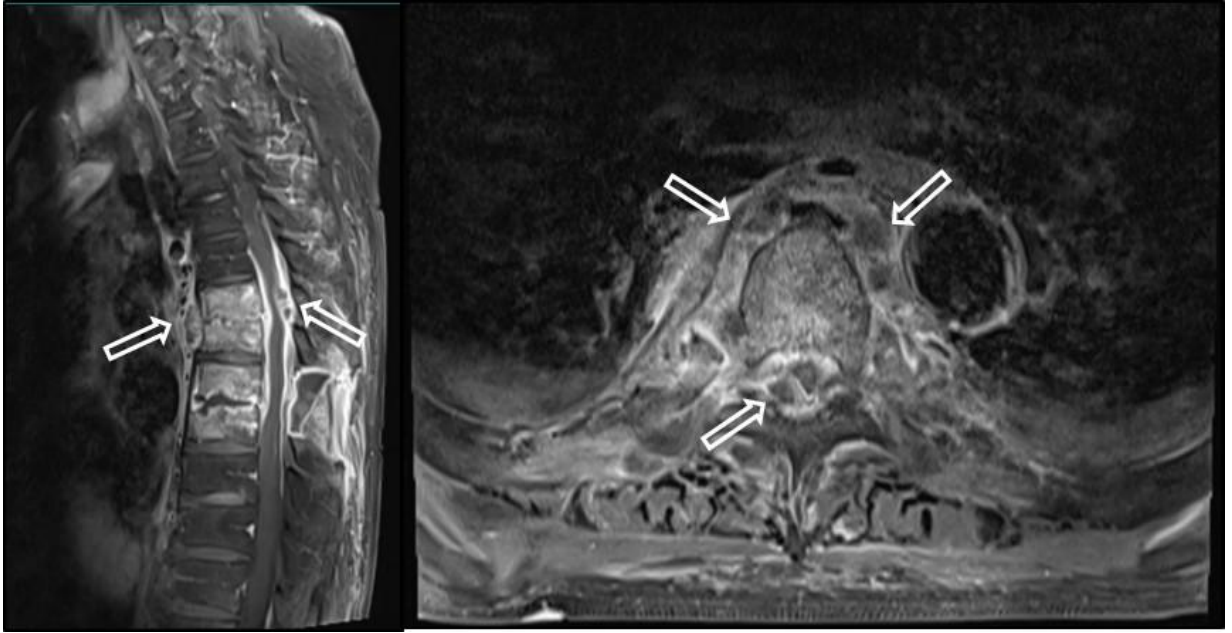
Thoracic spine T1-weighted magnetic resonance imaging with enhancement showed recurrent aggravated spondylitis with epidural abscess (white arrow) on the T6/7 and T8/9 vertebrae.
